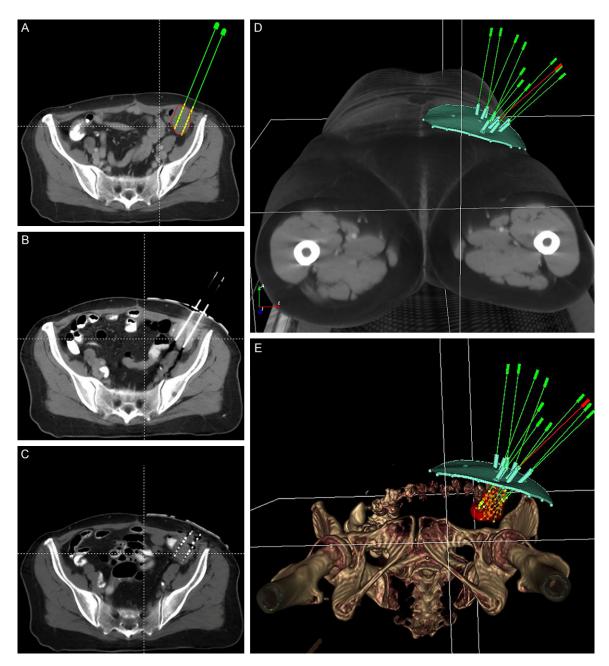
The CT images of pre-, intra-, and post-stereotactic ablative brachytherapy (SABT). (A) shows the preoperative treatment planning including the contouring of gross tumor volume (GTV) and distribution of puncture needles and seeds. The green needles and yellow seeds represent the actual needles and seeds; (B) shows the actual locations of needles during operation; (C) shows the actual distribution of seeds in GTV after operation; (D, E) show the model of personalized three-dimensional (3D)-printing template model in treatment planning system.
